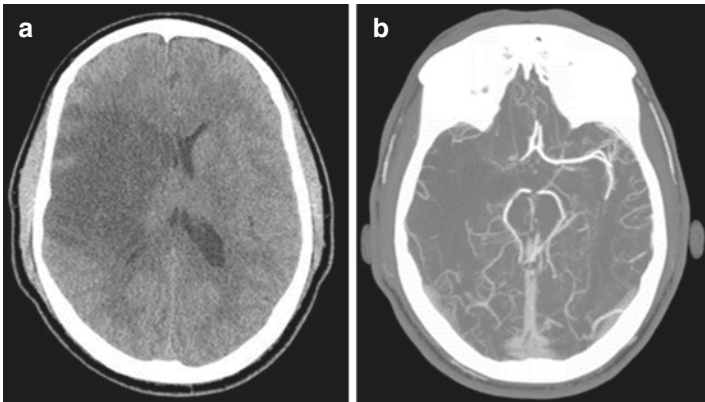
Non-contrast CT scan showing low density consistent with right middle cerebral artery infarct (a). Concurrently obtained CT angiogram showing occlusion of the right middle cerebral artery (b). And the CT perfusion studies highlighting the area of ischemia (c, d)
